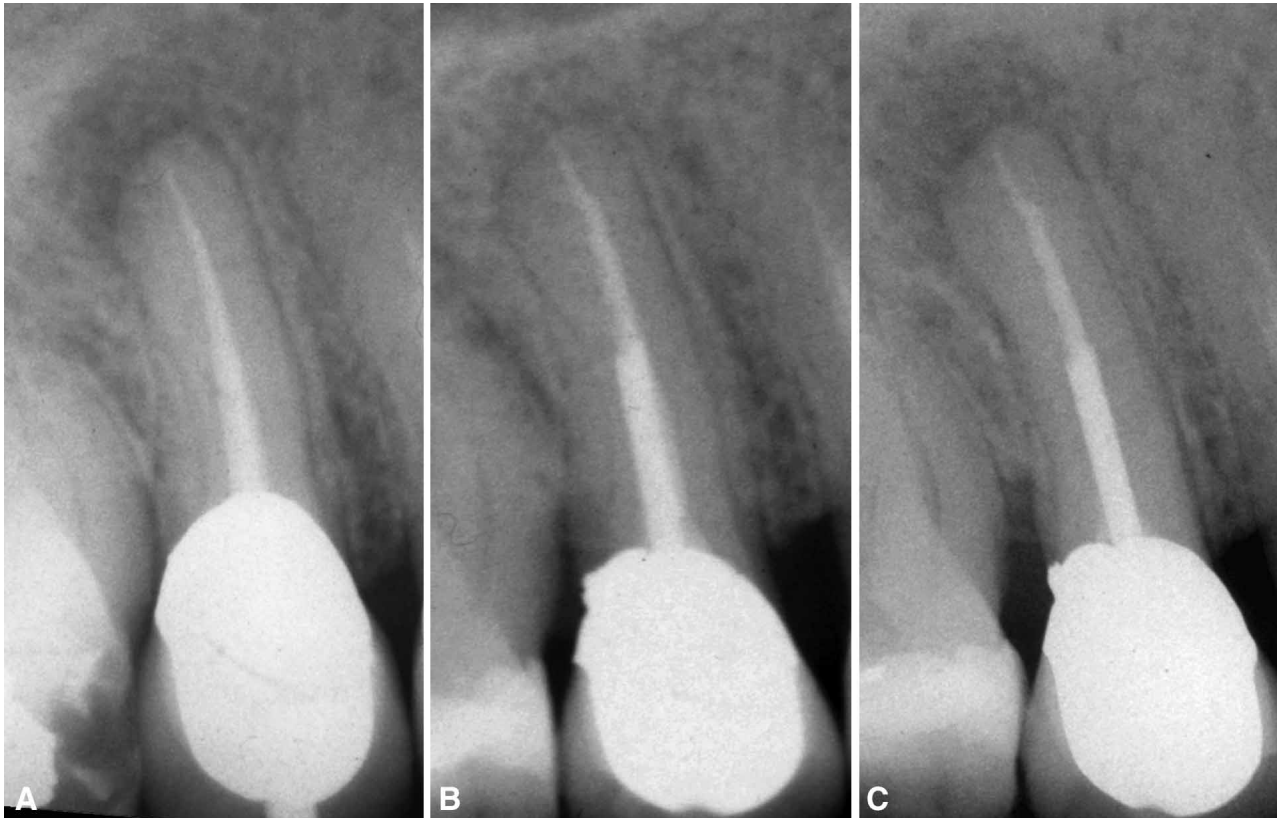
Recurrent disease after endodontic treatment. A. Immediate post-operative radiograph of maxillary second premolar with apical periodontitis. B. Apparent complete healing at 1 year. C. Recurred disease at 3 years.
